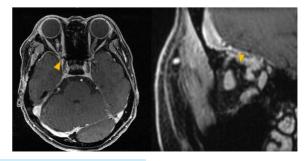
Postoperative MRI showed that the tumor had been completely removed, with no residual tumor.
